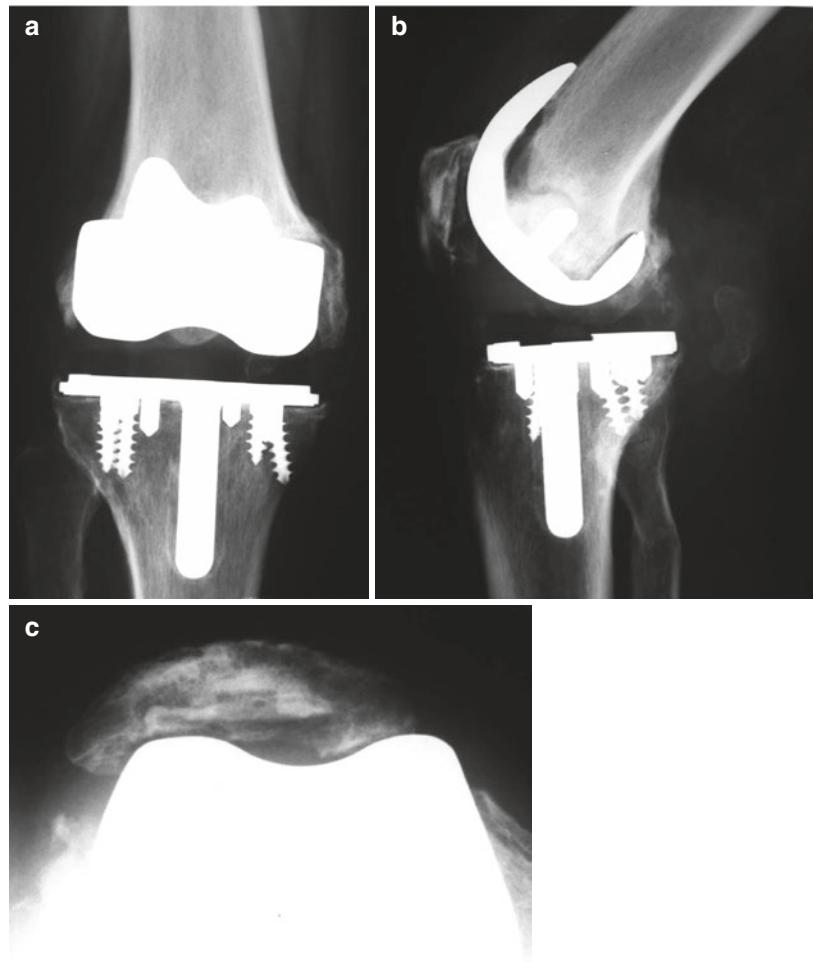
(a) Anteroposterior radiograph of failed revision total knee arthroplasty that had been performed for aseptic loosening with uncemented primary components. (b) Lateral view of failed revision showing aseptic loosening and extensive osteolysis in the femur. (c) Merchant patellofemoral radiograph showing resurfaced patella that is loose (circumferential radiolucency) with only the scaphoid-shaped anterior cortex as the residual bone. Once the prosthesis is removed, this bone will not fit well between the femoral condyles.
